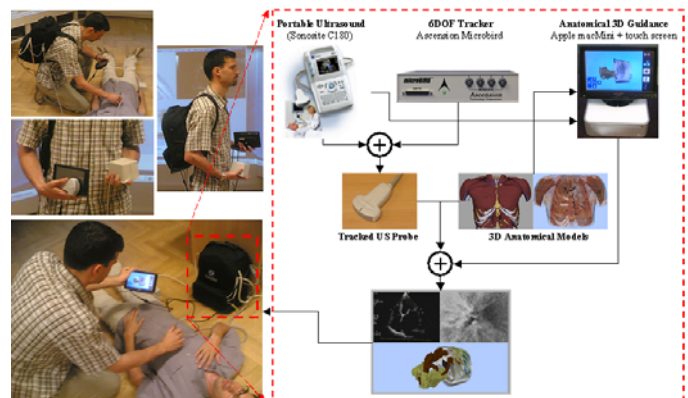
Overview of our backpack anatomically guided ultrasound system.
